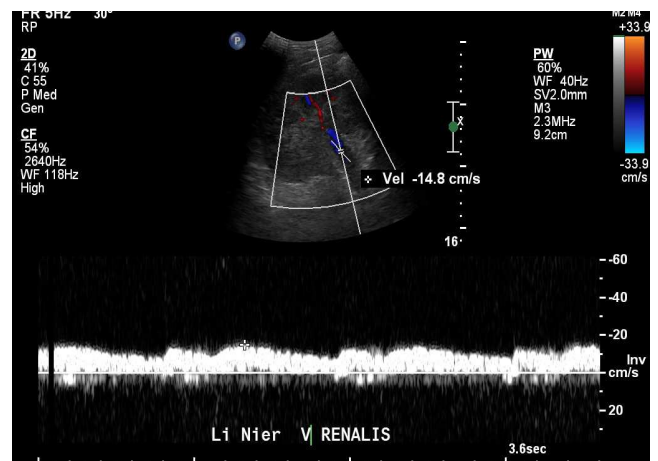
Doppler ultrasonography showed no decreased diameter of the left renal vein and normal bloodflow rate.
